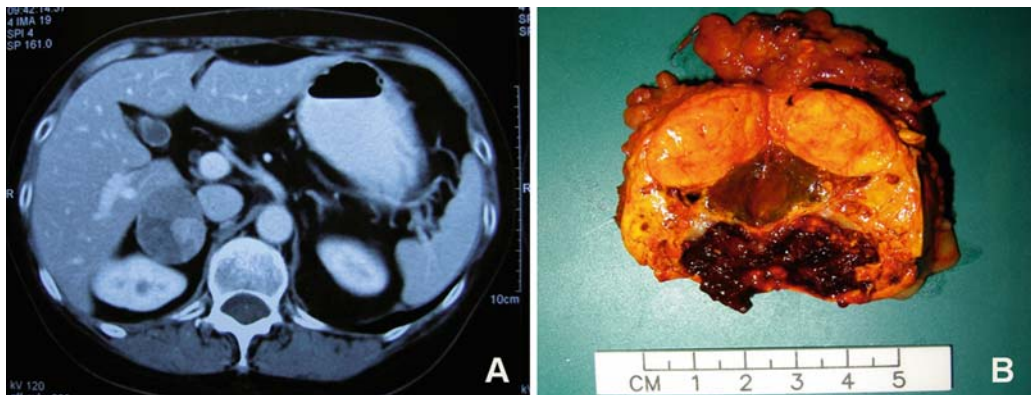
CT scan showing a 3-cm adrenal adenoma in a patient with biochemically confirmed Cushing's syndrome (A) and the resected adrenal gland revealing a typical golden-yellow adrenal adenoma (B).
